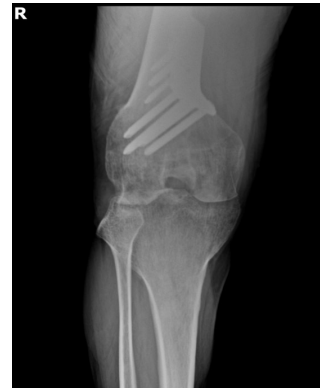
X-ray of the right knee. The scan showed a state of distal femur osteotomy.
